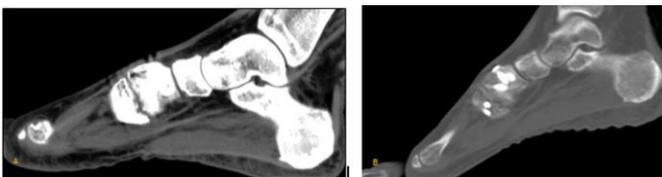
(A) CT confirmed non-union of 1st TMTJ arthrodesis. (B) CT confirmed central bony bridging across previously noted non-union 2 months after percutaneous BMA grafting.
